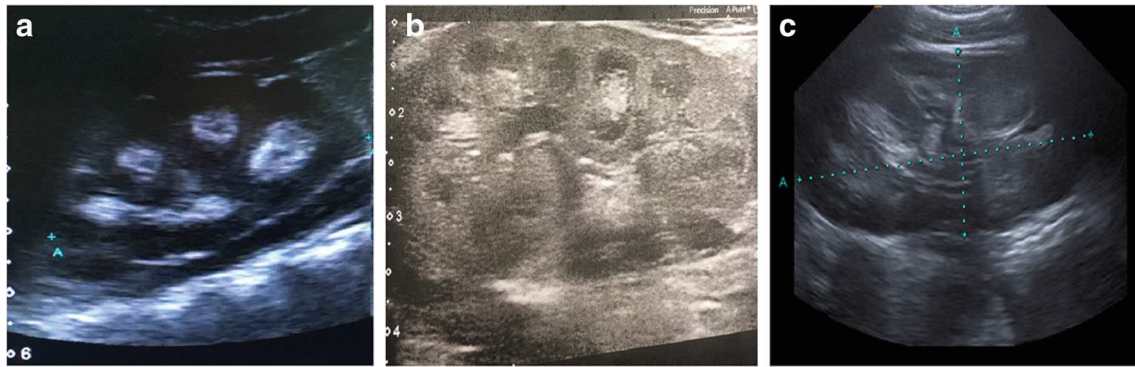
Postnatal ultrasound. a Case 1 at 2.5 months, b case 2 at 1.5 months, and c case 3 at 3 years
